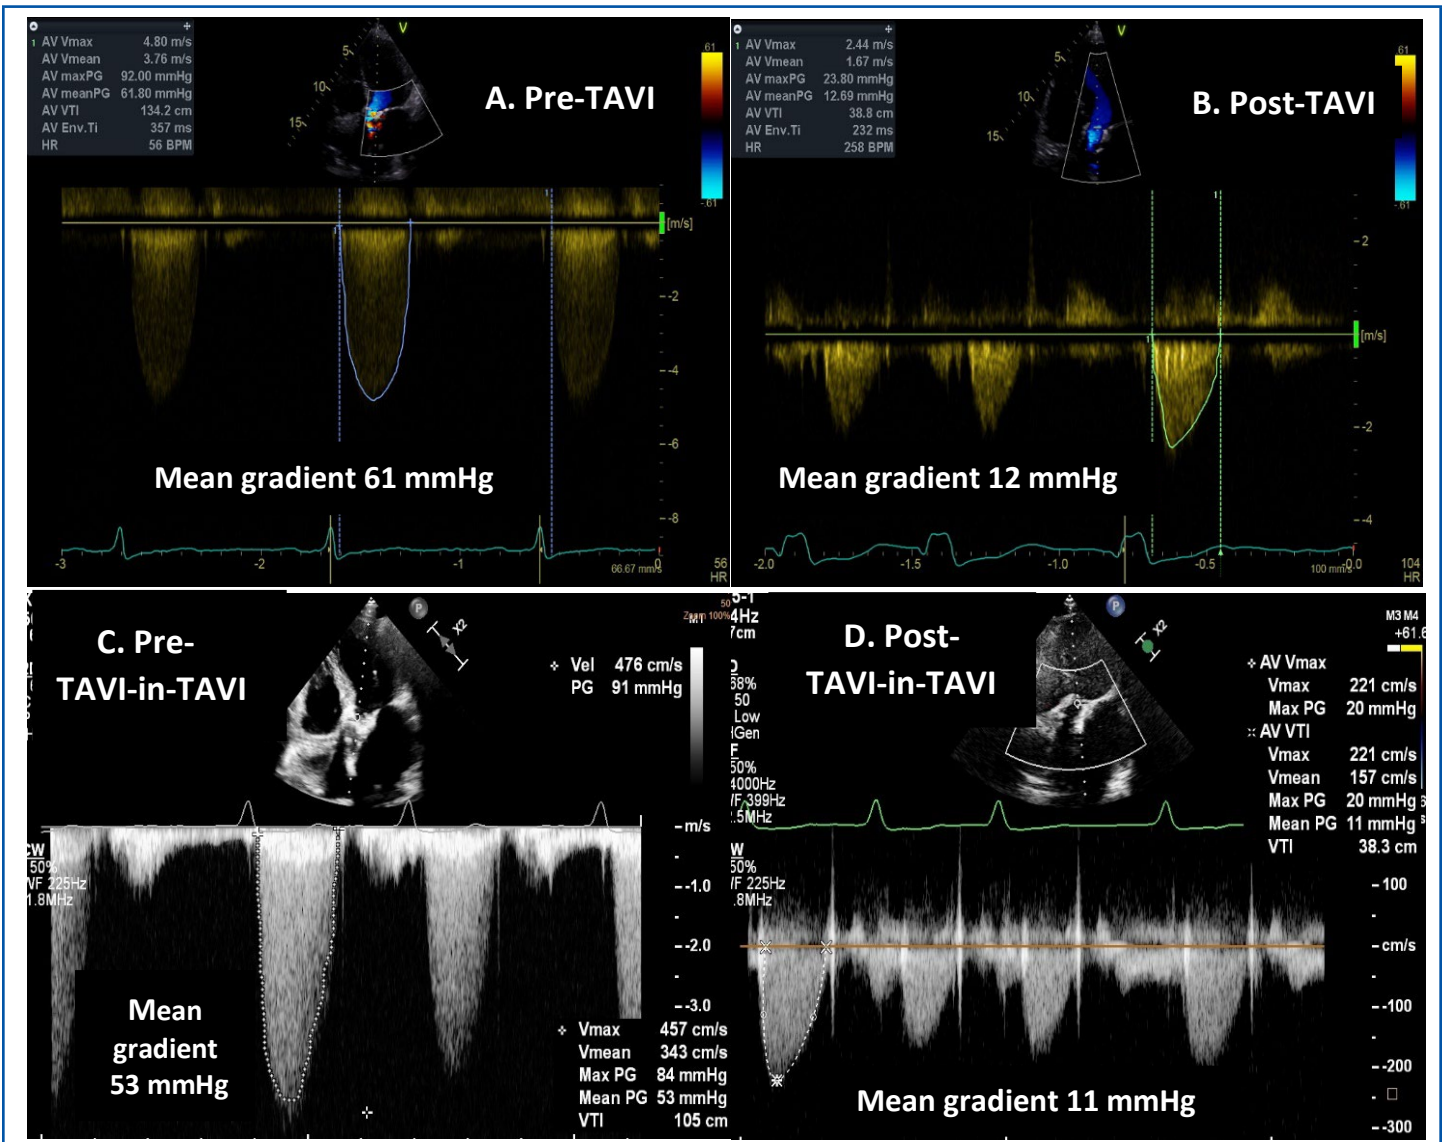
Evaluation of aortic valve function with continuous-wave Doppler echocardiography before transcatheter aortic valve implantation (A), after transcatheter aortic valve implantation (B), before TAVI-in-TAVI (C), and after TAVI-in-TAVI (D).
